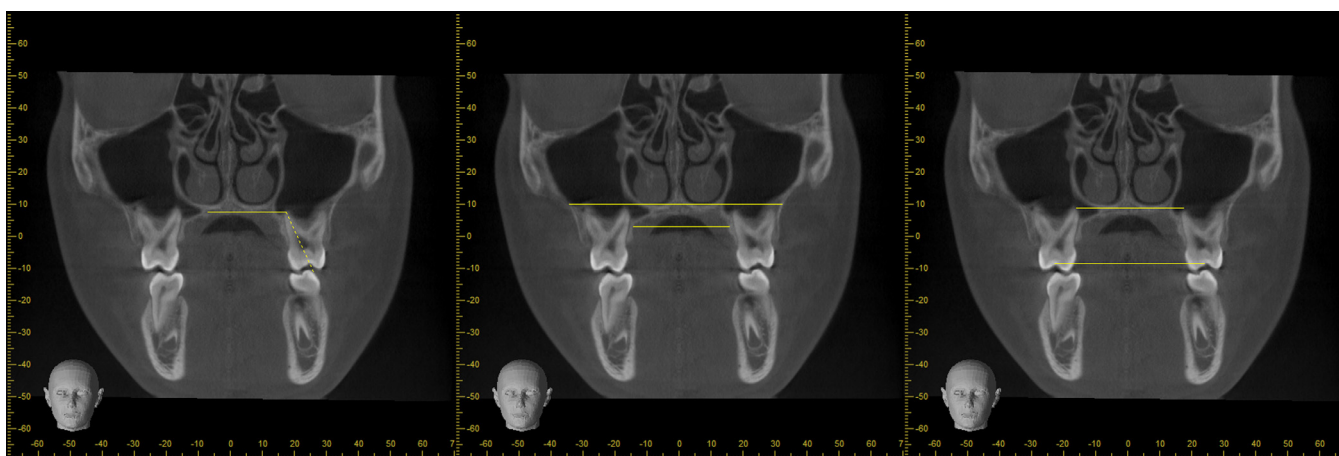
Coronal view of the CBCT for linear measurements (A) tipping angles of 16 and 26, (B) External and internal maxillary distance and (C) Palatal root and Central fossa distance.
